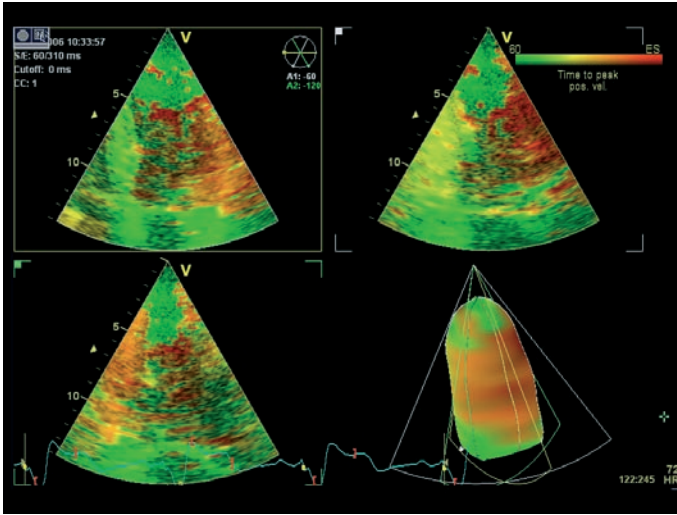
Example of tissue synchronization imaging applied to a triplane dataset. The areas of latest mechanical activation are indicated in orange/red in the apical 4-, 2- and 3-chamber views. The lower right panel shows a semi-automatically generated 3-dimensional LV volume portraying the area of latest mechanical activation.
